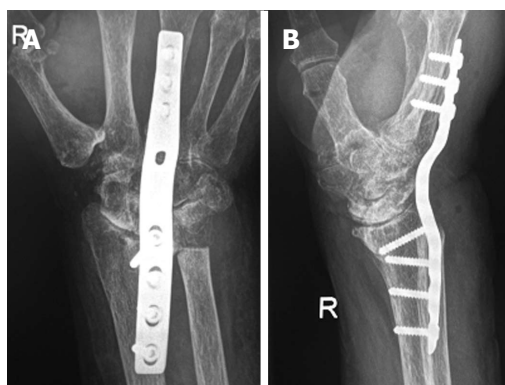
Postoperative X-ray after wrist arthrodesis of the hand seen in Figure 1. A: a.p.; B: Lateral view.
